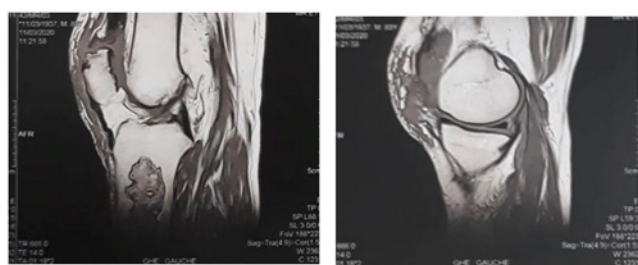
MRI images confirm the rupture of the quadriceps tendon.
